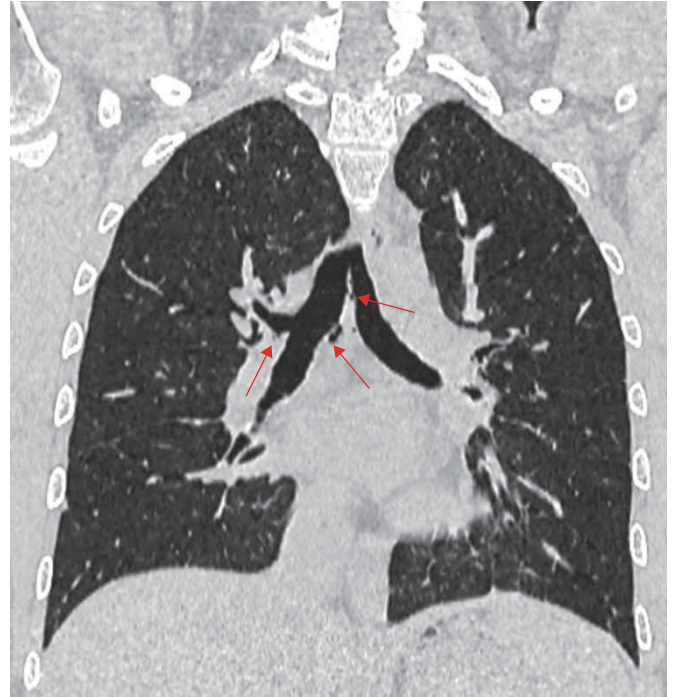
Bronchial diverticulosis in a pulmonary arterial hypertension patient carrying a *TBX4* mutation. Coronal image from high-resolution computed tomography with a maximal intensity projection of 2 mm.
